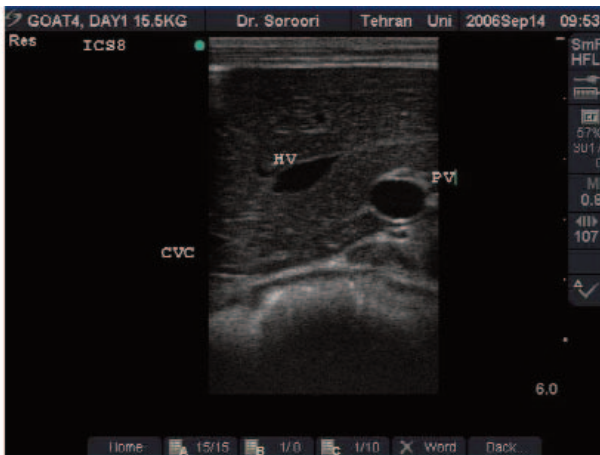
Ultrasonogram of the liver, portal vein, hepatic vein, and caudal vena cava. Transducer was placed in the 8th ICS. Hepatic vein is positioned dorsal to portal vein and ventral to caudal vena cava. PV: Portal vein; HV: hepatic vein; CVC: caudal vena cava.
